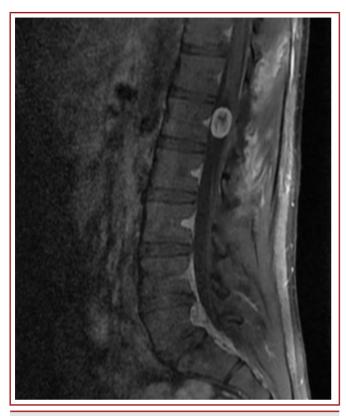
Preoperative lumbar spinal tumor sagittal MRI image
